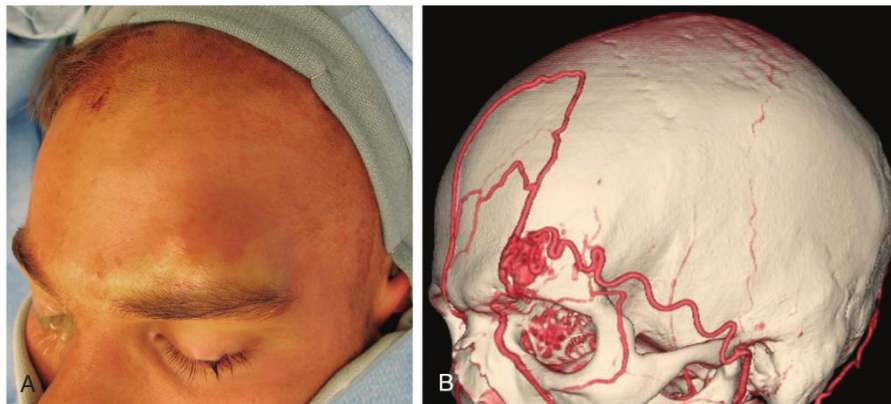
Computed tomographic angiography (B) and clinical appearance (A) of quiescent arteriovenous malformation nidus, left brow.
